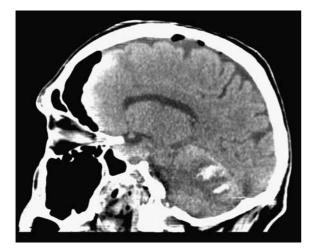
Case 2: Sagittal CT-scan of the brain showing haemorrhage in the upper vermis within the folia of the cerebellum
